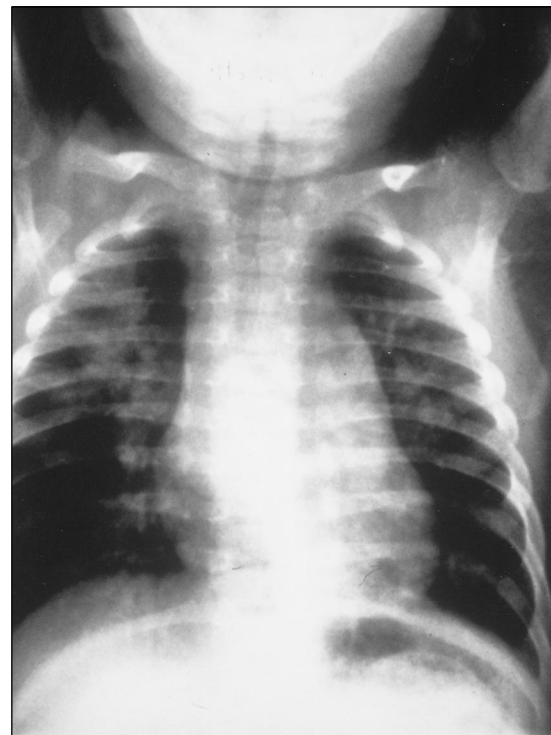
Findings on chest radiography of a 6-week-old infant who has chlamydial pneumonia include hyperexpansion and bilateral diffuse interstitial infiltrates, with some alveolar densities in both upper lobes.
